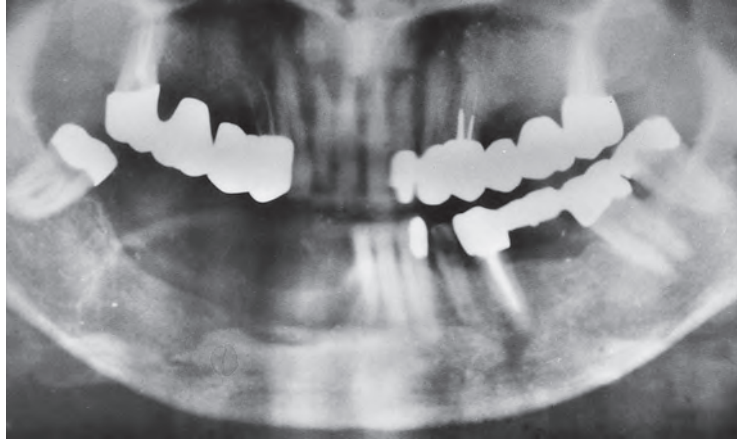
A panoramic radiograph showing a lytic lesion of the mandible on the right-hand side (arrow).
